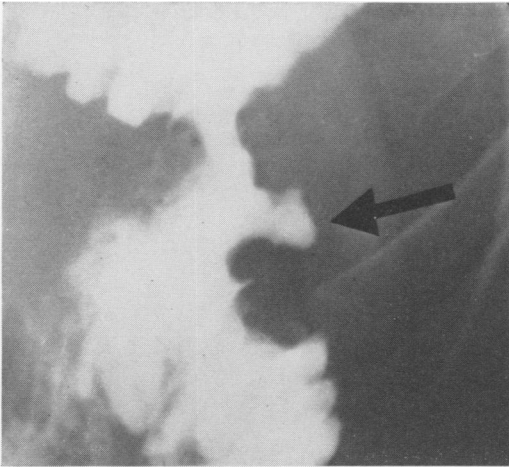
Photograph of x-ray showing the second large jejunal ulcer. This subsequently healed following transthoracic vagotomy.
